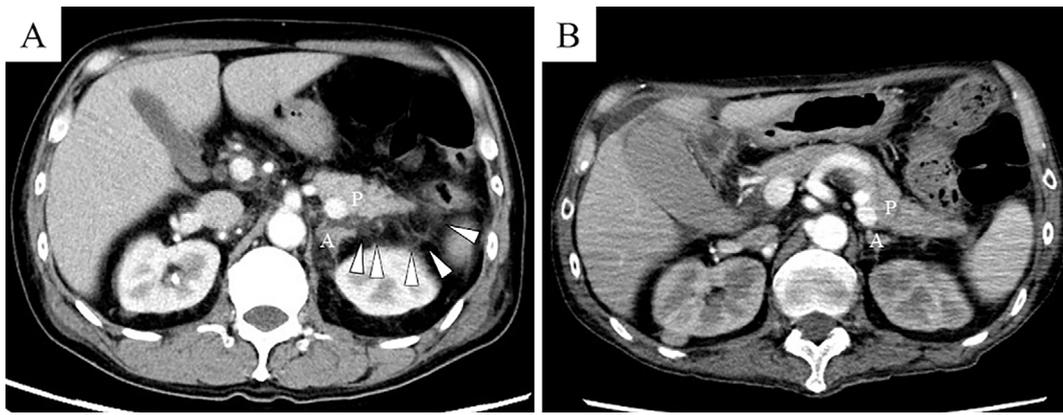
Contrast-enhanced computed tomography (CT) at the disease onset (A) showed high-density retroperitoneal panniculus surrounding the corpus and tail of the pancreas with a contrast effect (arrows). CT also showed perirenal edema. After the administration of therapeutic agents for three months, both the density of retroperitoneal panniculus and perirenal edema decreased (B). P: pancreas, A: adrenal gland
